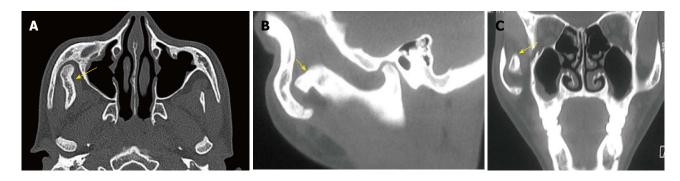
Jacob's disease in a 17-year-old boy presenting with restricted mouth opening. Axial (A), sagittal (B) reformatted computed tomography images depict "pseudo-joint formation" between enlarged coronoid process of mandible and zygomatic arch (arrows).
